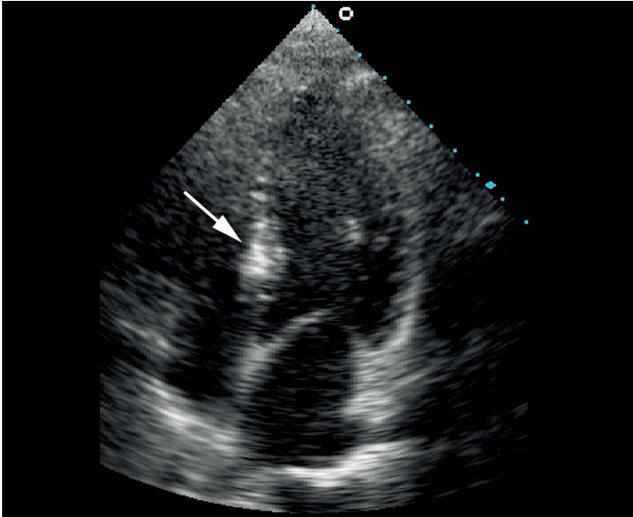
Echocardiogram (4-chamber view) of a 20-year-old woman with tuberous sclerosis complex shows a focal area of increased echogenicity in the interventricular septum (arrow).
